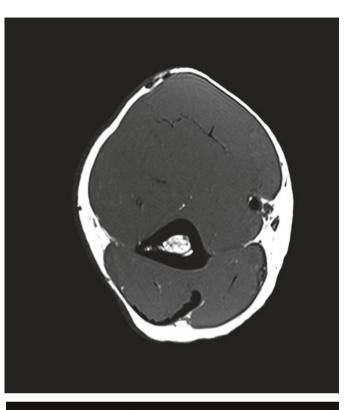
MRI scans at the proximal third of the arm through the radial nerve
